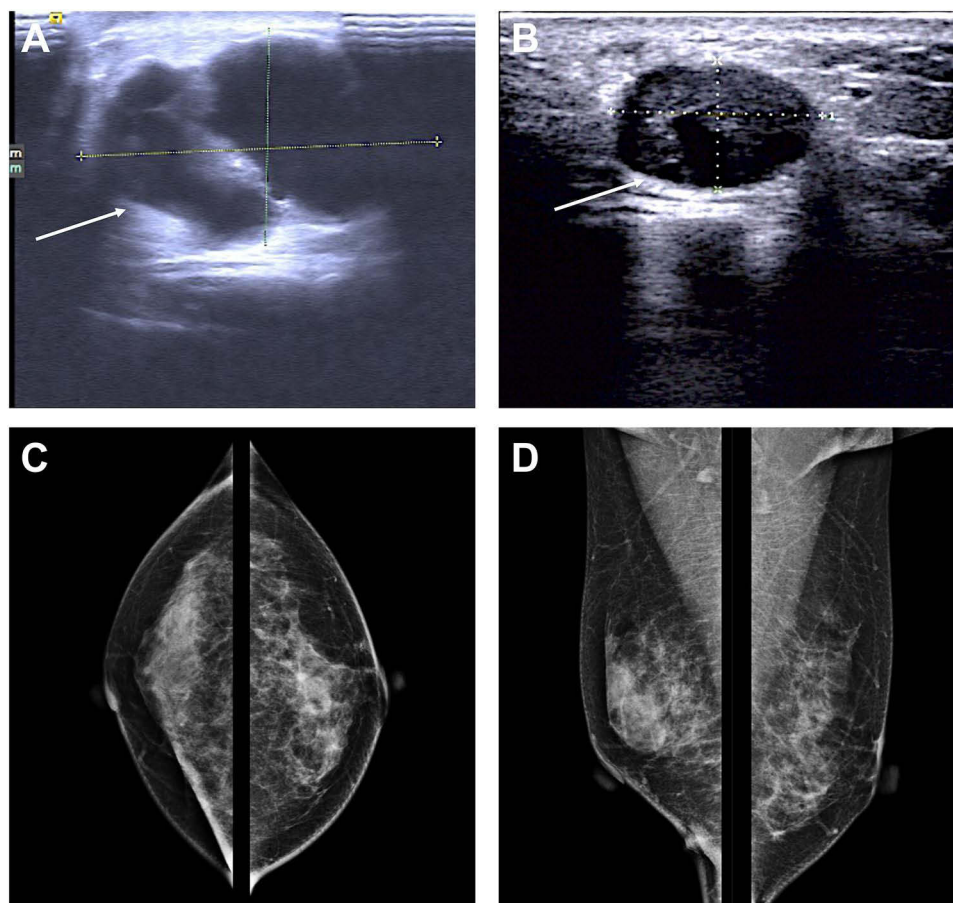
Breast ultrasound and mammography images.
